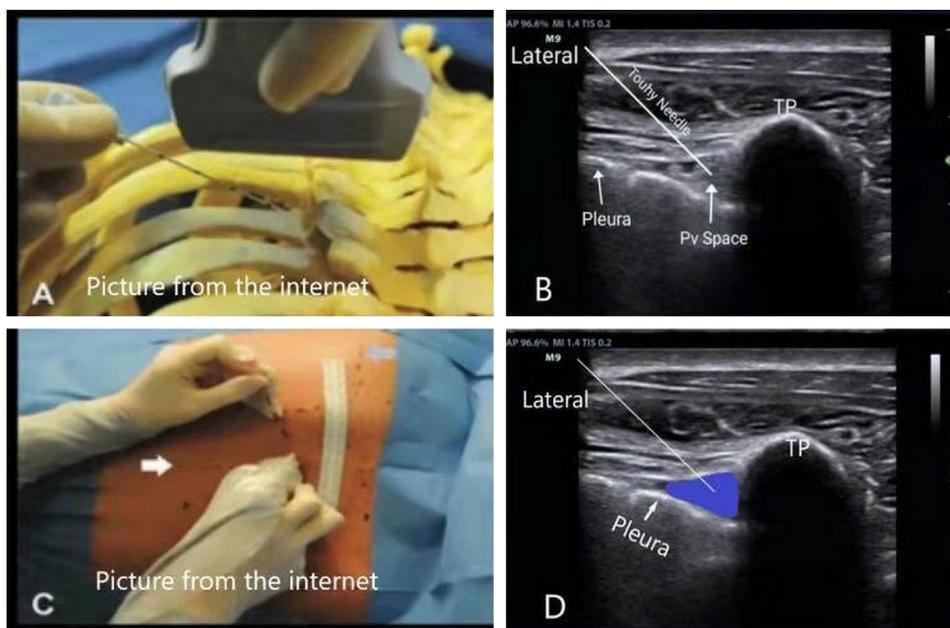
A view of ultrasonic guidance with needle puncture achieved paravertebral space in the study.
